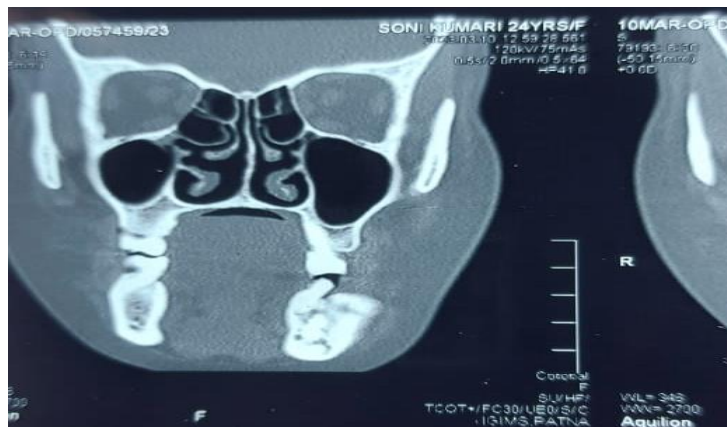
[a] The coronal sections of contrast-enhance computed tomography shows left side radiopacity with thin radiolucent rim surrounds it
